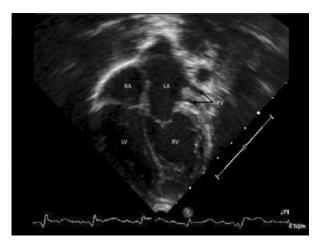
A two-dimensional echocardiographic image demonstrating congenitally corrected transposition {S, L, L}. The septal surface of the right-sided ventricle (LV) is smooth, consistent with a morphologic left ventricle. The left-sided ventricle (RV) is heavily trabeculated and appears to have chordal attachments to the septal surface, consistent with a morphologic right ventricle. Pulmonary veins (PV) can be seen entering the left-sided atrium (LA), consistent with a morphologic left atrium.
